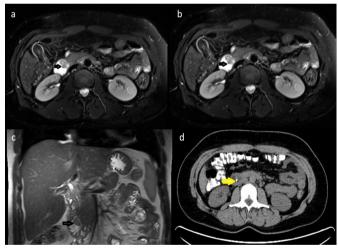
Abdominal magnetic resonance imaging shows a mass (black arrows) inside the duodenal lumen on topography of duodenal papilla (a, b and c). PET/CT (FDG) shows hypermetabolic area (yellow arrow) on topography of duodenal papilla (descending part of duodenum) (d).
